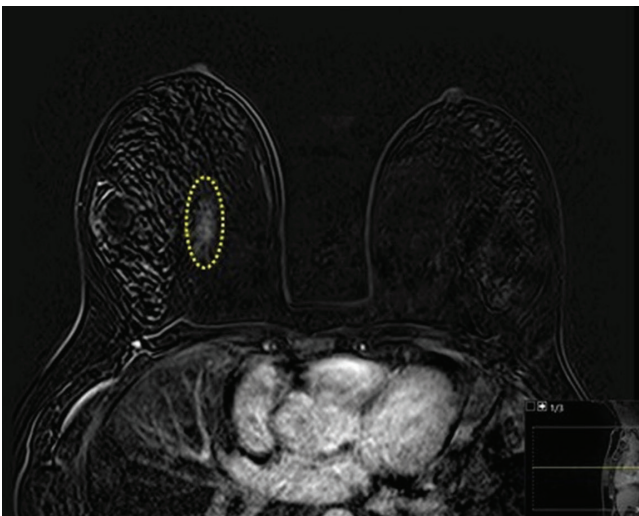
Dynamic, contrast-enhanced MRI subtracted image showing a weak non-mass enhancement in the upper inner quadrant of right breast
